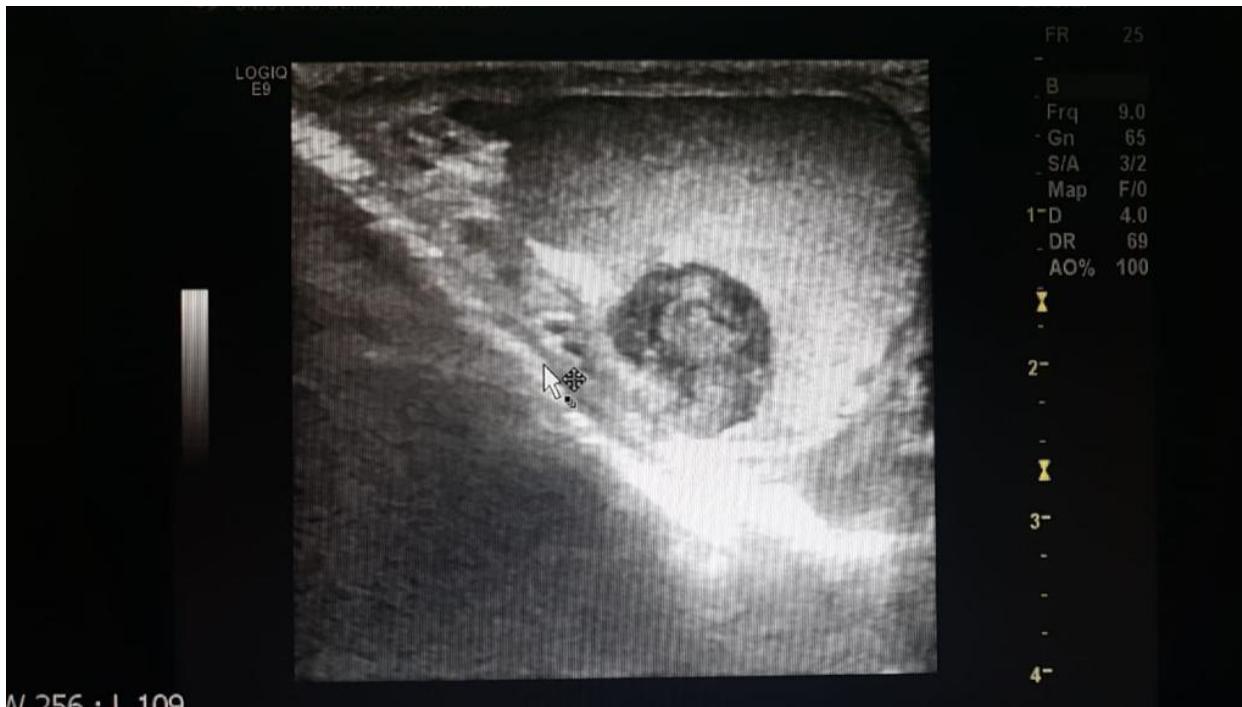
18-year-old male with a testicular epidermoid cyst. Transverse grey-scale sonogram of the right testis identifies a well-demonstrated heterogeneous mass.
